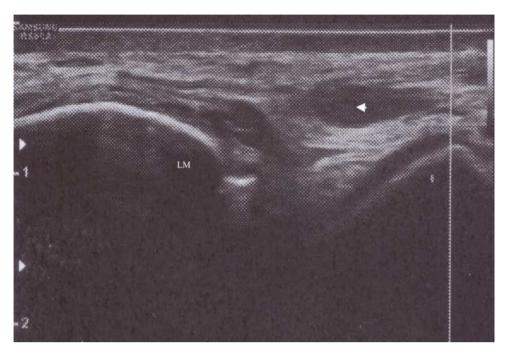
Ultrasound imaging: the peroneus longus tendon (arrowhead) is dislocated proximal to the peroneal tubercle (§); the peroneus brevis tendon is not discernable from the bone surface of the calcaneus where it lays, between the lateral malleolus (LM) and the peroneal tubercle.
